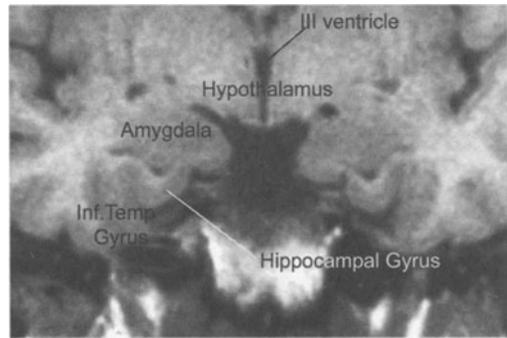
Coronal Section through amygdala and hypothalamus. MRI-T1. Hippocampal gyrus = parahippocampal gyrus
